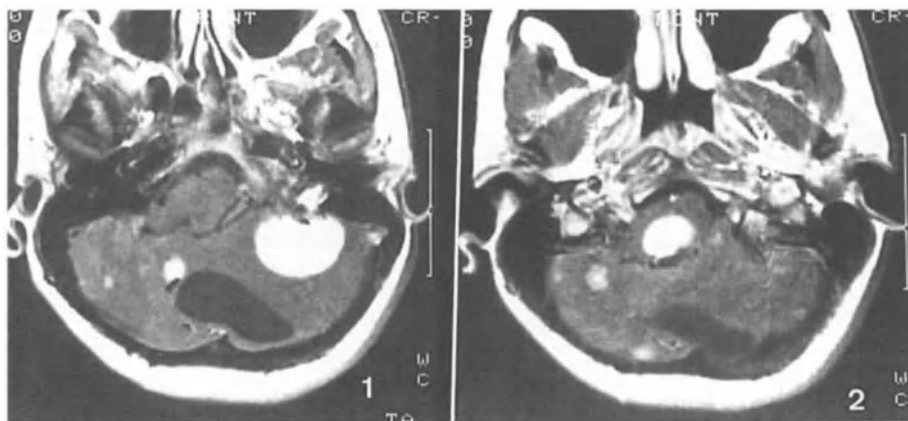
CNS haemangioblastomatosis: T1-weighted MRI (TR 60, TE 15, Gd-DTPA). Note the enhanced signal of the numerous tumoural nodules demonstrated at two levels (1 and 2) of the posterior cranial fossa and the low-signal of cystic components
